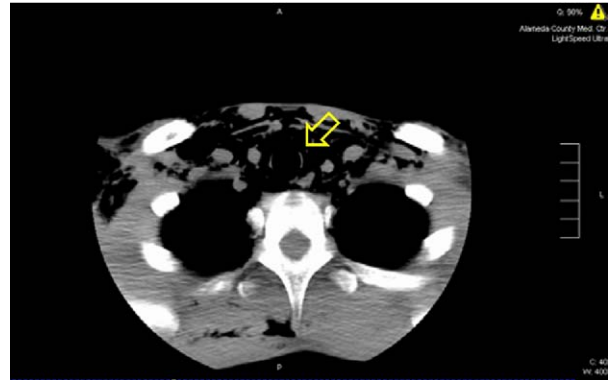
Chest CT scan showing pneumomediastinum (arrow).
